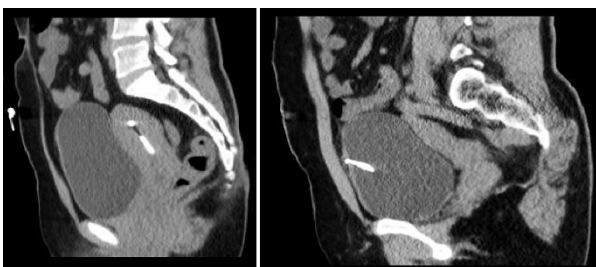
CT scan showing IUD in the bladder and uterus
